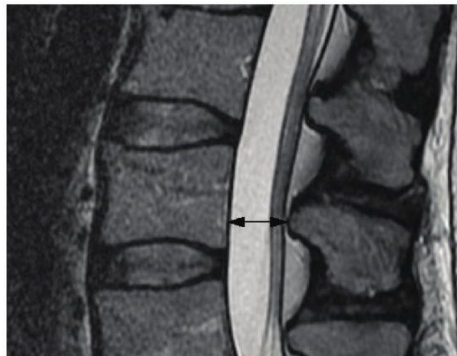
T2 weighted sagittal fast spin echo MR image of the middle lumbar spine. The black arrow indicates the antero-posterior diameter of the osseous spinal canal.
